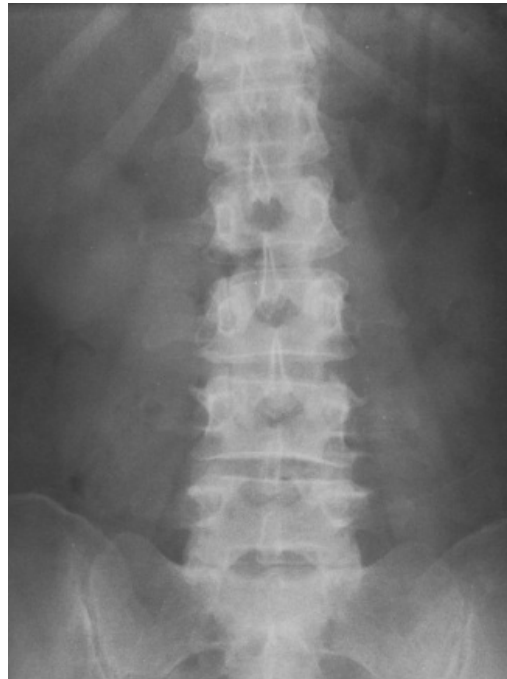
Example of anteroposterior radiograph 2D (AP view) are clearly image.
